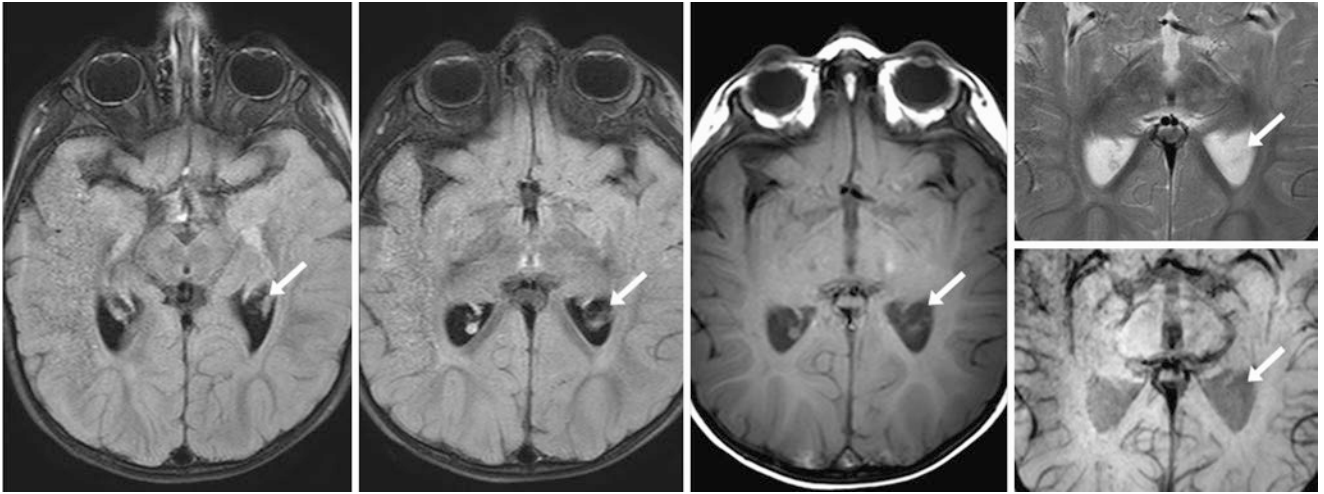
A 13-month-old infant with a mild developmental delay but lacking evidence of syndromic or other abnormality on clinical examination and on a 3 T MRI. A CPC (arrows) was incidentally noted within the left lateral ventricle on axial FLAIR (left and left middle) and on
